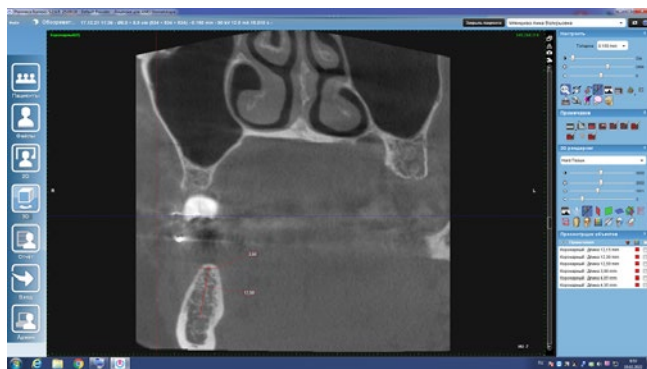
Calculation of CT before surgery
